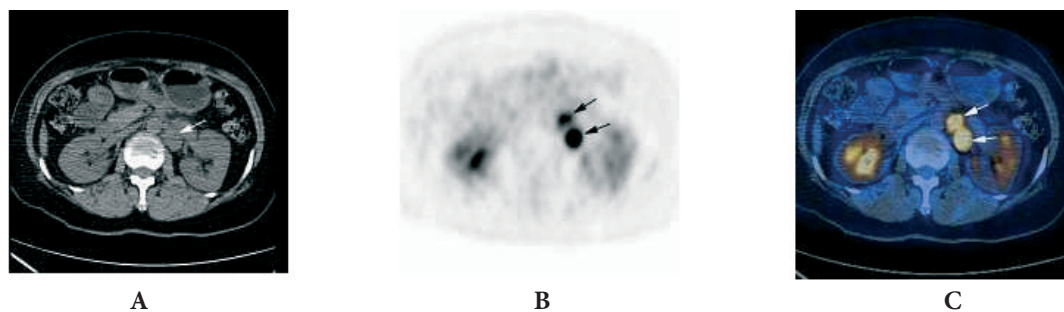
40-year-old man with lung adenocarcinoma was a true-positive case confirmed by surgical excision. A. An unenhanced CT scan shows a mass (white arrow) on the left adrenal gland. B. PET shows two discrete masses with increased uptake (black arrows) on the left adrenal gland. C. Integrated PET/CT shows two discrete masses with high uptake (white arrows) on the left adrenal gland.
